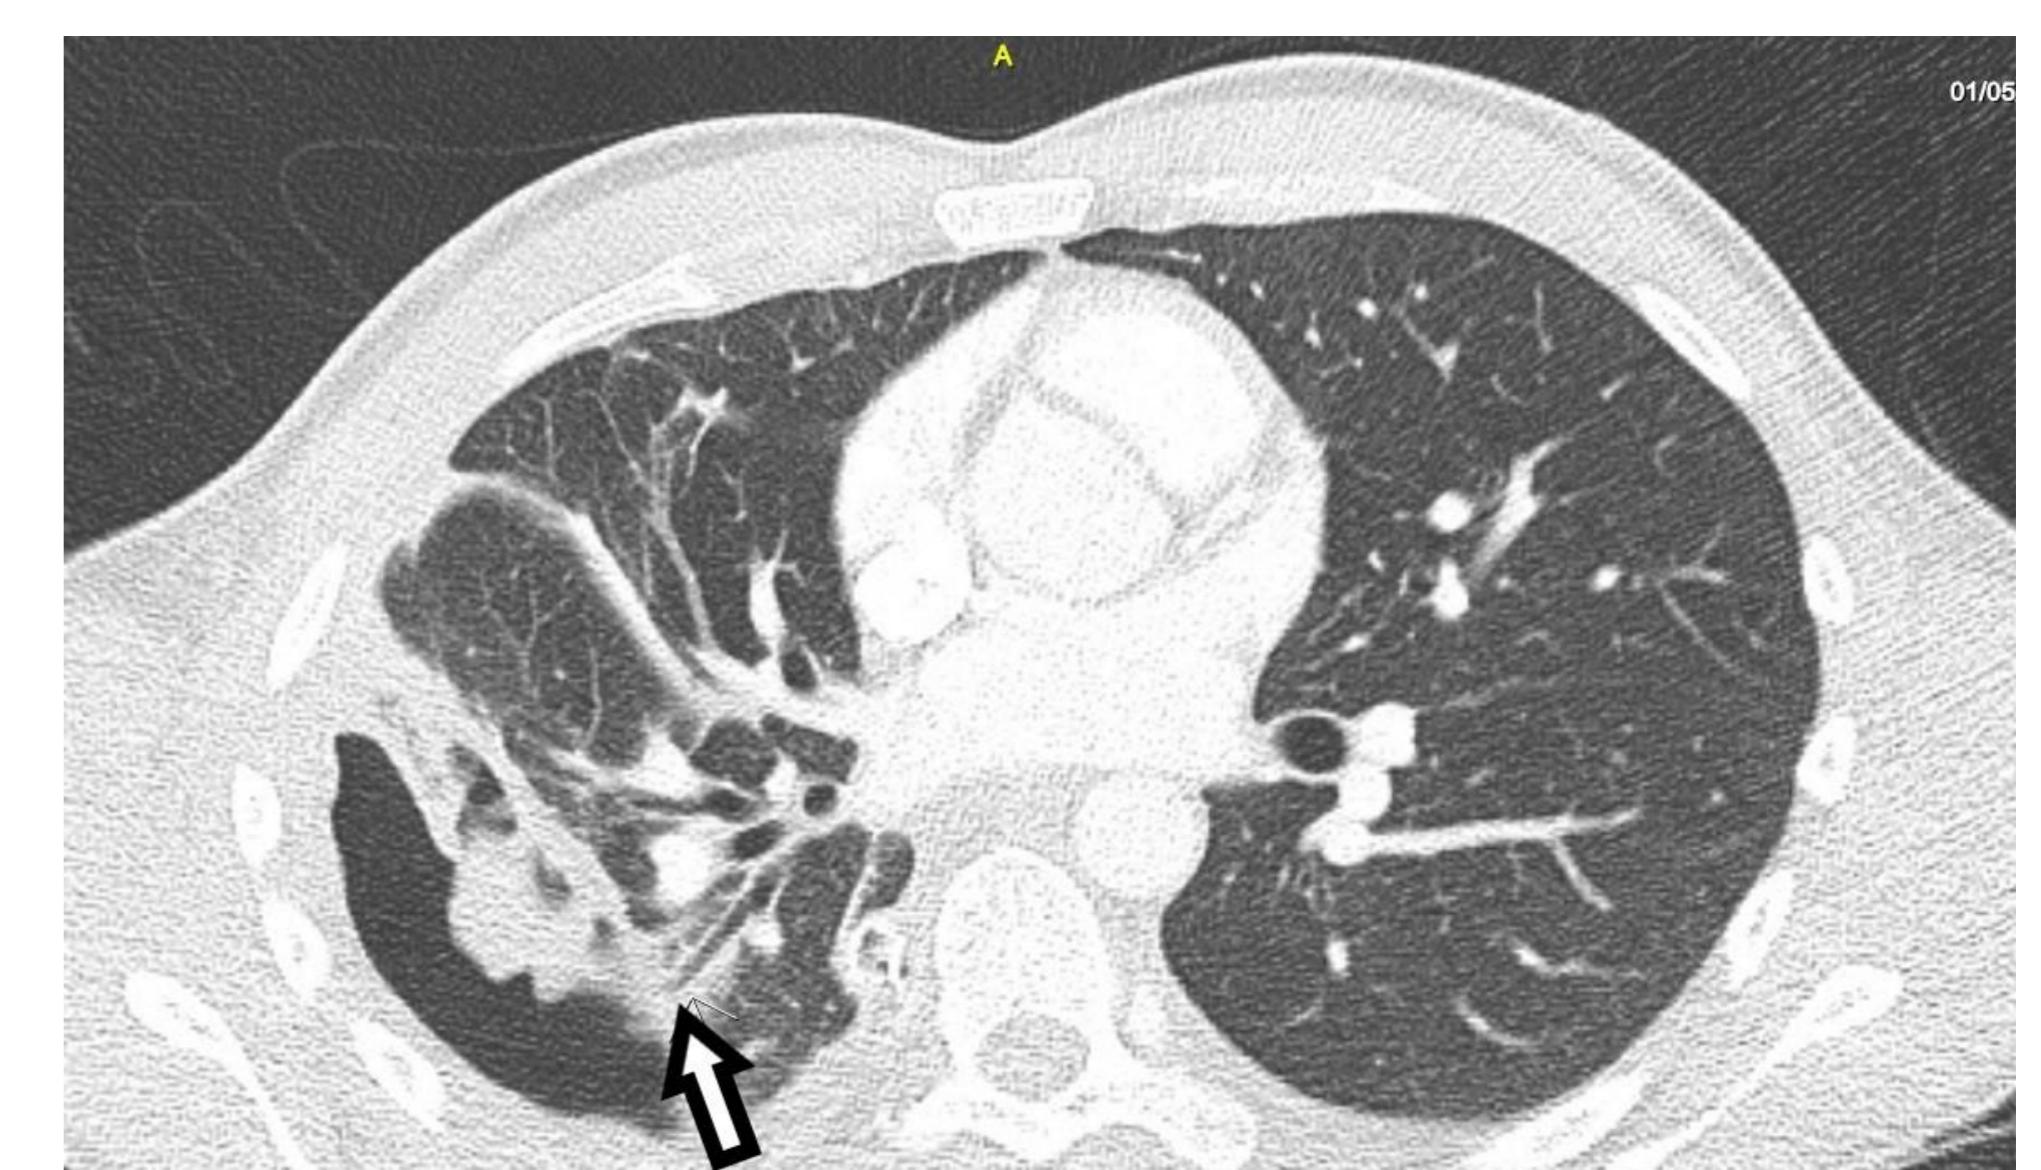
CT scan showing a BPF
